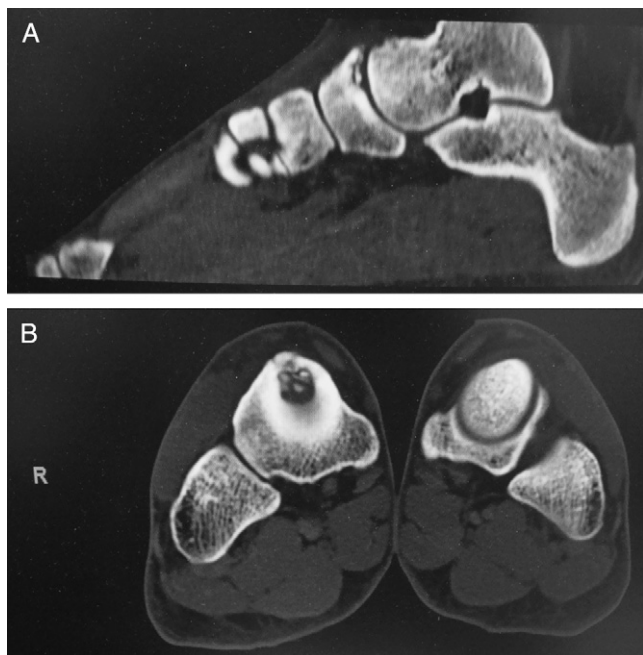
(A) Preoperative lateral computed tomography scan of patient 1. (B) Frontal computed tomography scan of patient 1.
